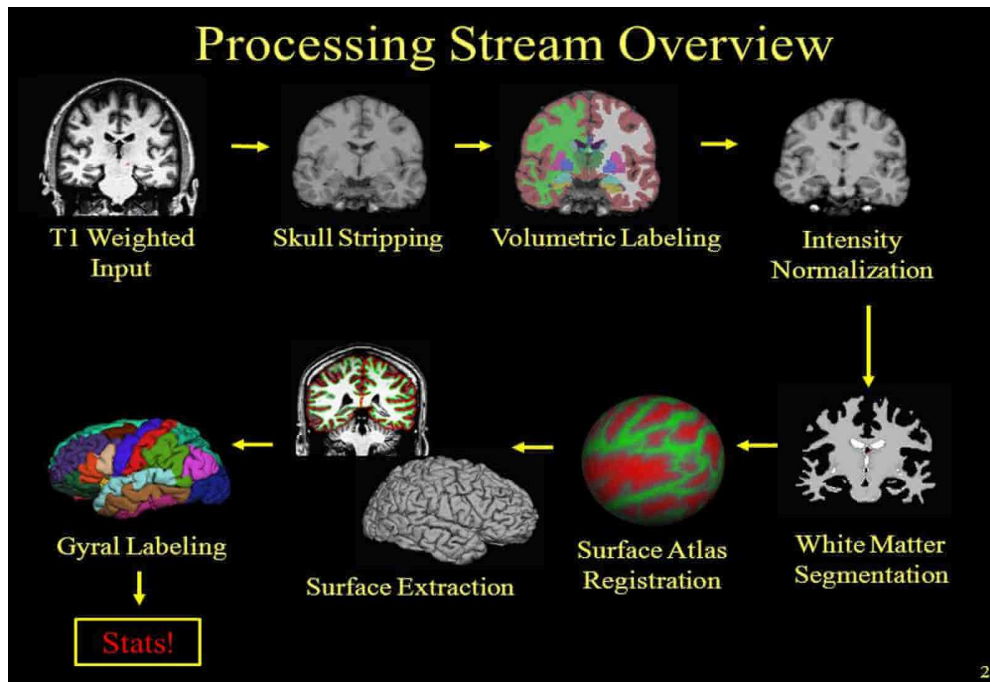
Full processing stream of FreeSurfer for MRI data (from <http://www.opensourceimaging.org/project/freesurfer/#>; August 28, 2018)
